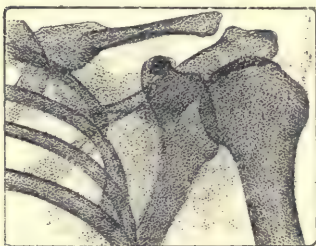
Radiograph of the left shoulder seen from front. It will be noticed that the shadow of the free extremity of the coracoid process resembles a slightly deformed shrapnel bullet. The resemblance is still more perfect on the screen. This aspect is however much less accentuated if the shoulder is examined from the back (see Fig. 93).
